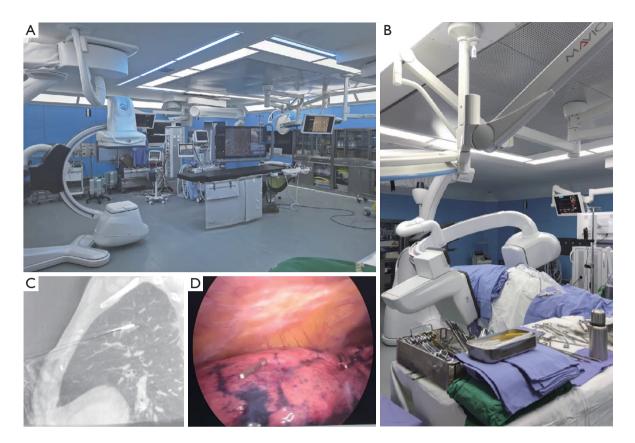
Hybrid operation room and procedures. (A) Hybrid operation room in our hospital. (B) C-arm X-ray machine (the Discovery IGS 7 angiography system, GE) which was used for supporting intraoperative localization procedures in our cases. Meanwhile, this machine was also used for localizing small nodules in VATS. (C) One of CT images of chest which were taken by our C-arm X-ray machine in our ablation procedures to help adjusting the location of microwave ablation needle. (D) In our previous research, an advanced way to localize small peripheral pulmonary nodules for surgical resection was reported (8). This figure shows that a titanium clip (Ethicon endo-surgery 1 ligaclip extra ligating clip cartridge 6 M titanium clips LT 300) was clipped at the visceral pleura under VATS observation to localize small peripheral pulmonary nodule with the help of baseline scan and preoperative CT imaging which was taken by our C-arm X-ray machine in the surgery. VATS, video-assistant thoracic surgery; CT, computed tomography.
